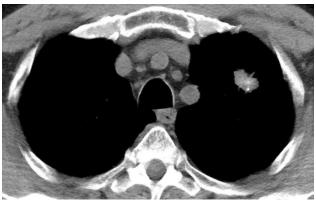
CT scans of the chest showing another tumor in the periphery of the left upper lobe. LUNG CANCER
